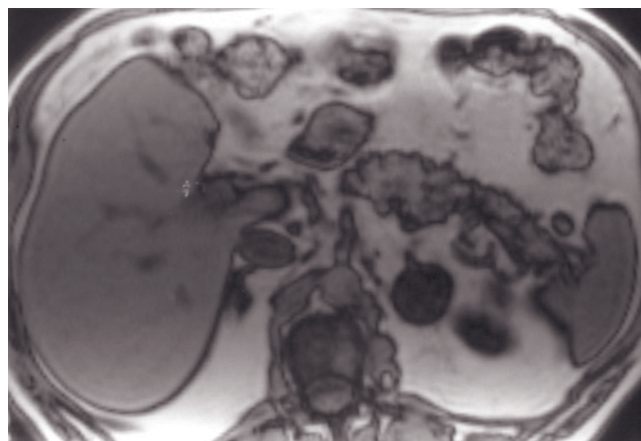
Adrenal adenoma. Coronal T1-weighted GE (a), T1-weighted GE (b), T1-weighted out-of-phase GE (c), immediate postgadolinium GE (d), and 90-s postgadolinium fat-suppressed GE (e) images. A 3×2 -cm right adrenal mass shows signal intensity drop on the out-of-phase image (c) compared to the in-phase image (b). The extent of signal intensity drop is consistent with substantial intracytoplasmic lipid. Immediately after contrast the adenoma demonstrates an early and homogeneous capillary blush (d), which washes out on delayed image (e).
